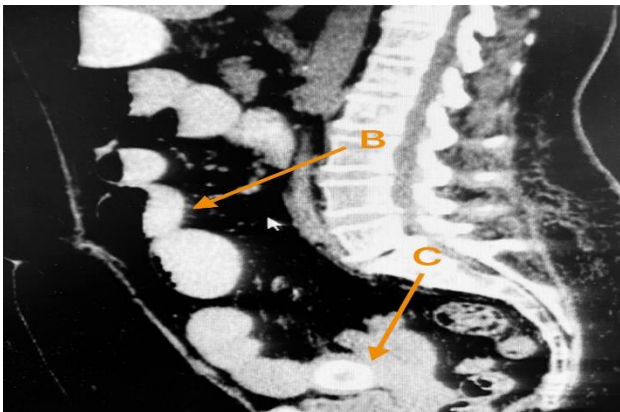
(B) Dilation of small intestine loops, and (C) presence of a gallstone in the ileum visualized by abdominal computed tomography in sagittal section.
